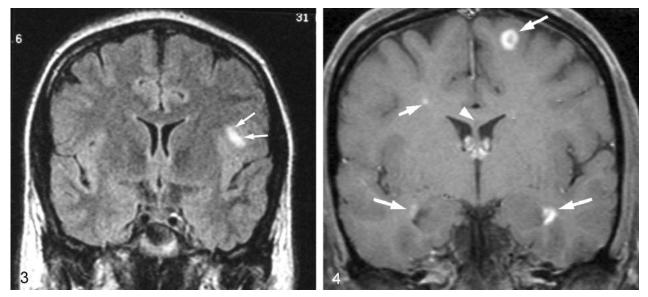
Coronal FLAIR-weighted image (TR/TE, 10,002/168) obtained at the level of the anterior horns of the lateral ventricles shows a focal area of increased signal intensity (*arrows*) in the subcortical white matter of the inferior frontal lobe on the left side.
